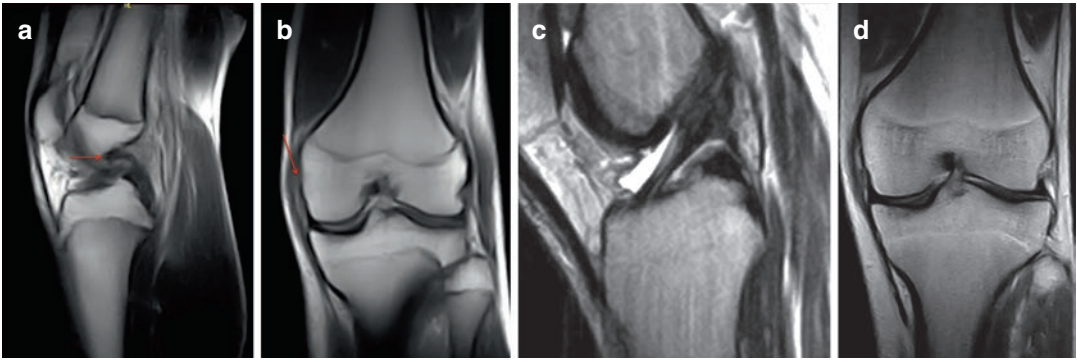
(a–d) Static and dynamic MRI scans demonstrating a full-thickness lesion of the anterior cruciate ligament and the medial collateral ligament, which are not clearly depicted in static scans
